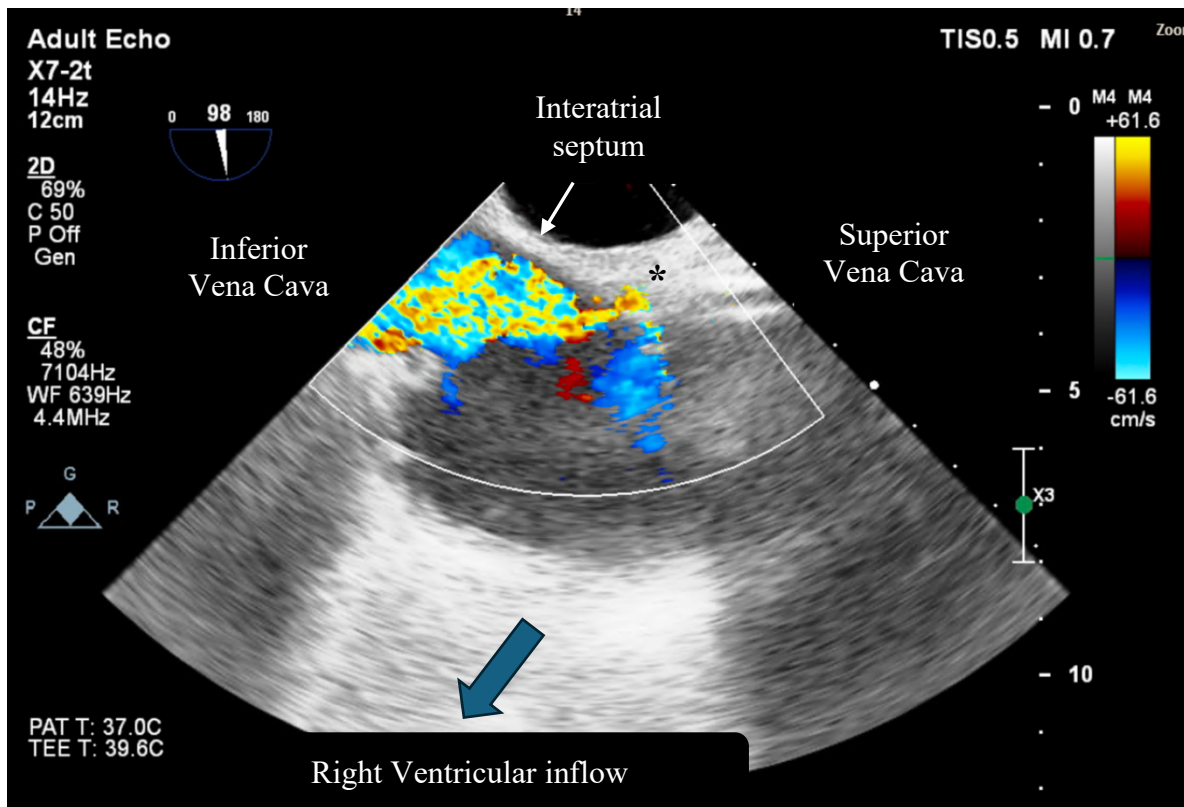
Transoesophageal echocardiogram: bicaval view, demonstrating return cannula at the superior vena cava-right atrial junction* with jet of blood oriented towards the drainage cannula (not seen) residing in the inferior vena cava. This is a situation in which high degrees of recirculation may be seen clinically.
